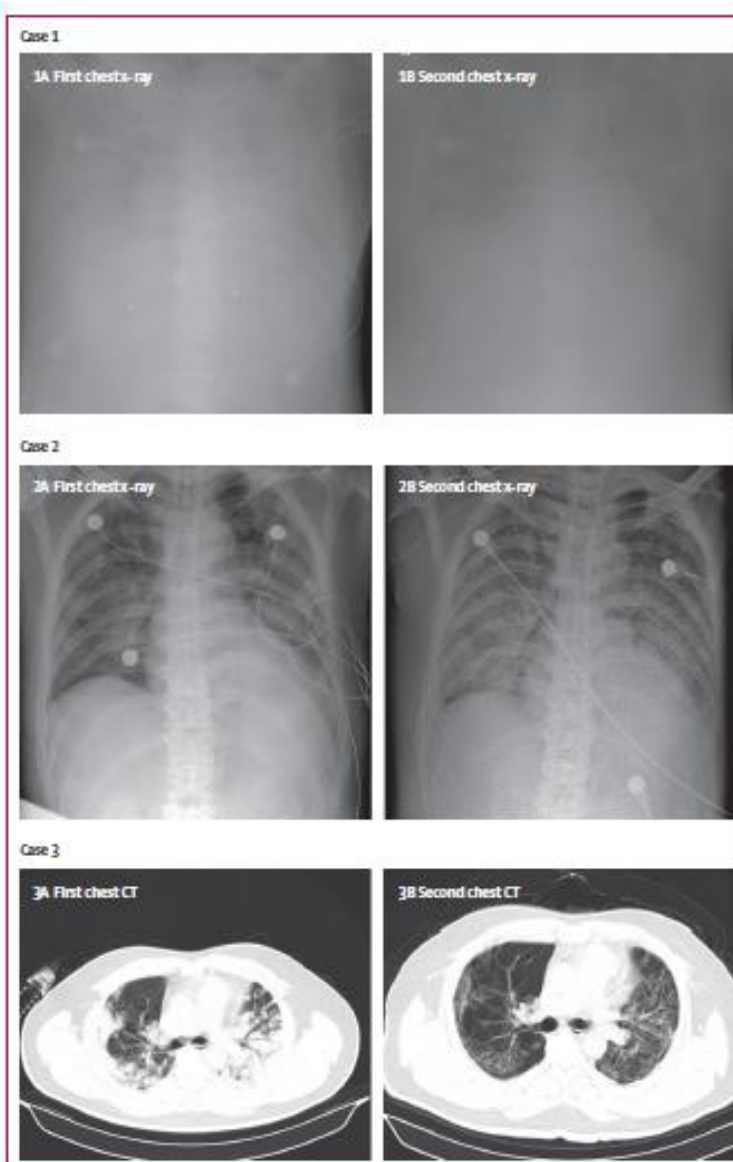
Chest x-rays and chest CTs of three patients
